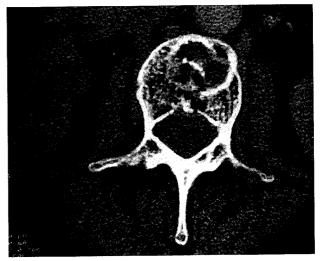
Computed tomography: heterogeneous appearance of the body of L2.
